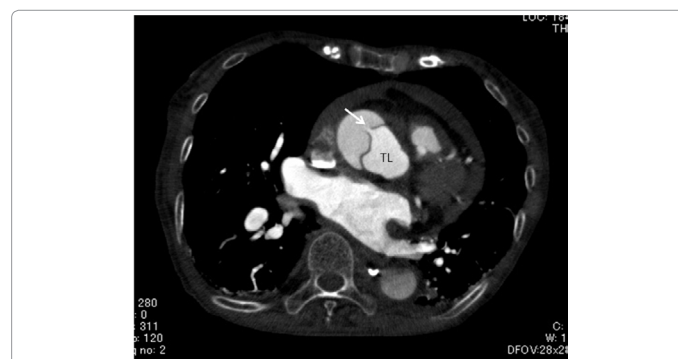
78 years-old female. Contrast enhanced computed tomography scan demonstrating acute type A aortic dissection with intimal flap and an entry (arrow) in the ascending and cardiac tamponade. TL: true lumen.
